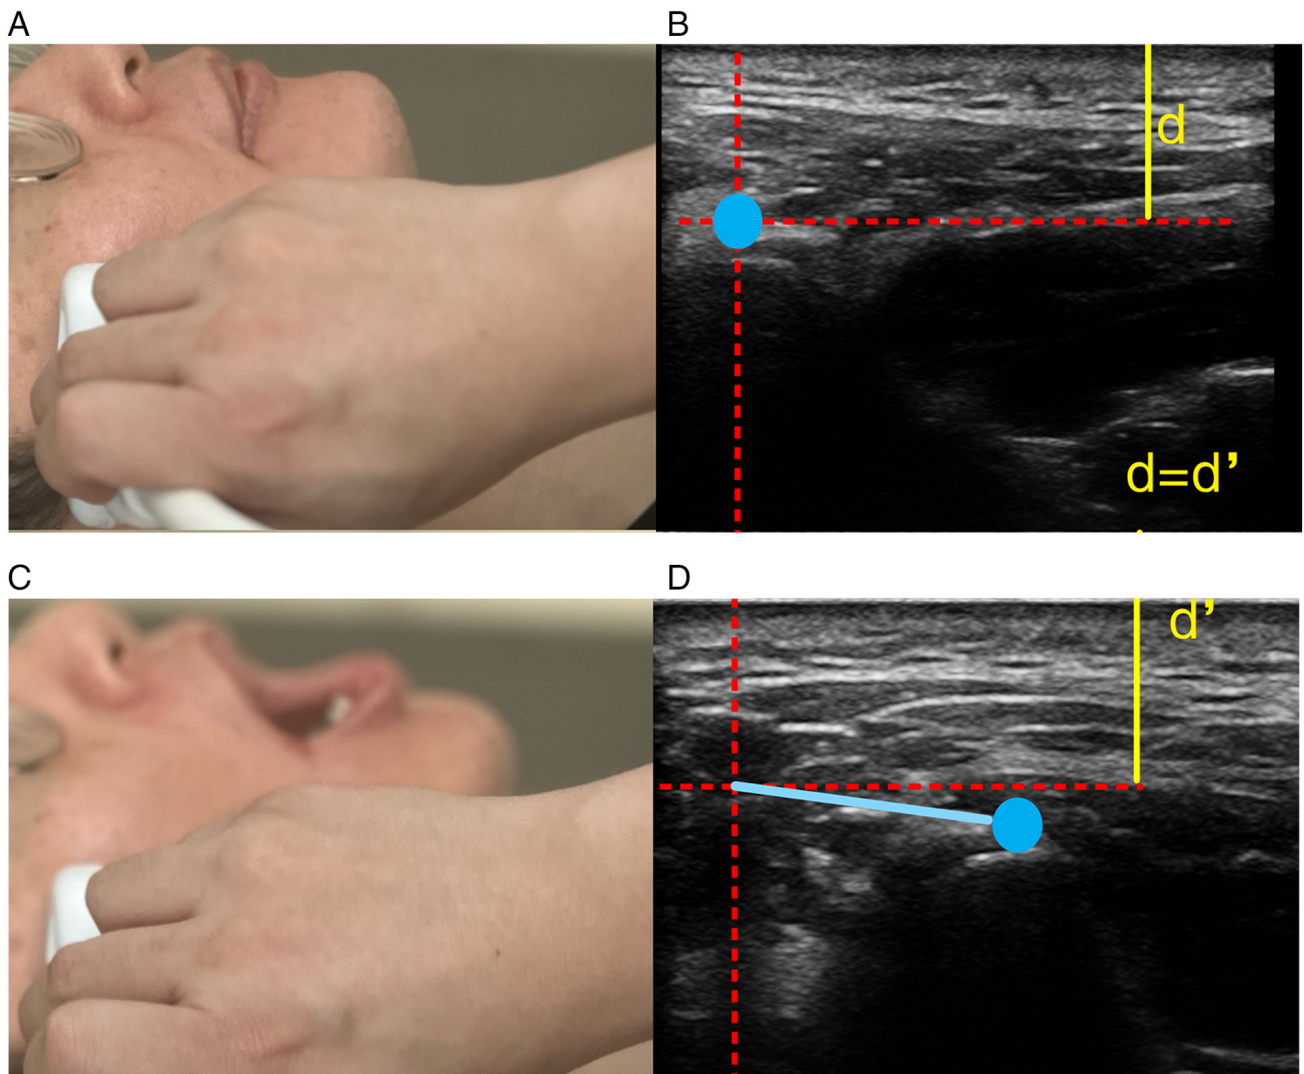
Method of applying high-frequency linear array ultrasonic probe to evaluate condylar mobility of temporomandibular joint. (A) Patient's position in shut mouth and place of ultrasonic probe. (B) The anterior condyle (the blue dot). (C) Image of ultrasound in opened mouth. (D) Anterior condylar translation (the blue line).
